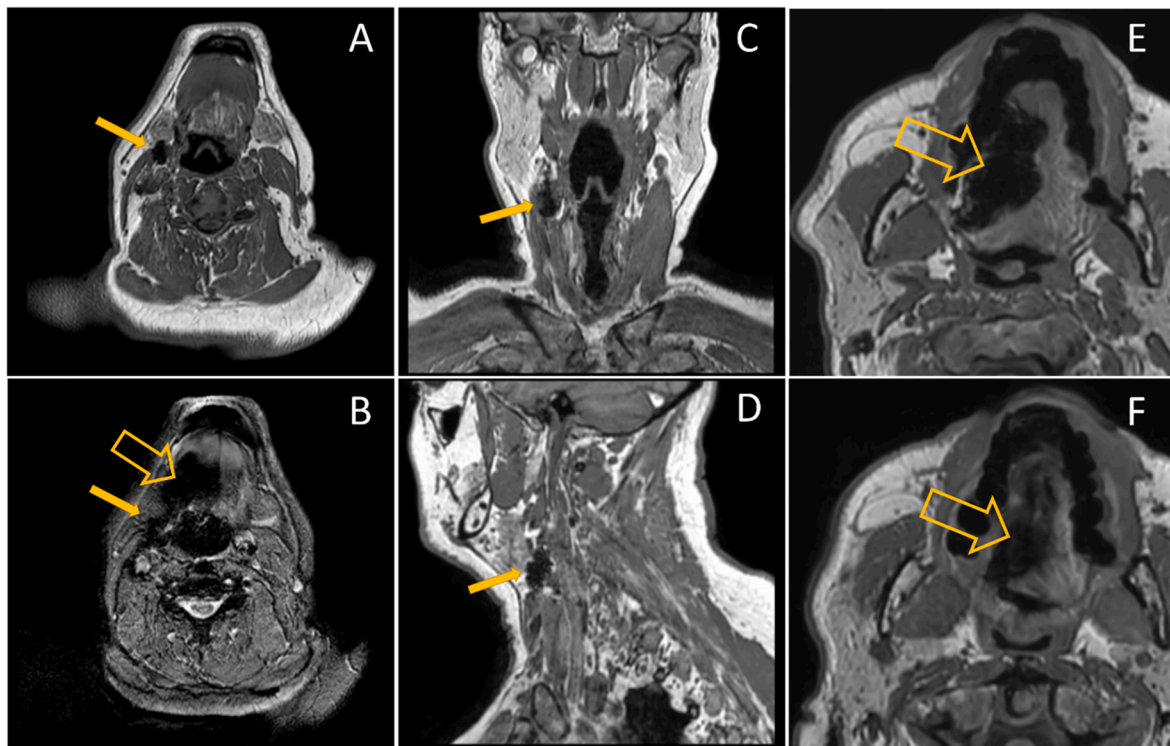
MRI data post magnetic tracer injection (A-E) and post-surgery (F). Solid yellow arrows show SLN (magnetic tracer uptake) in level IIa, right side (A-D). Open yellow arrows show tracer injection sites (B, E and F). (A) T1-weighted MRI (transversal plane); (B) T2-weighted MRI (transversal plane). The open yellow arrow points at the injection site, tumor at right side of tongue; (C) coronal reconstruction of Figure 2A; (D) sagittal reconstruction of Figure 2A; (E) preoperative MRI, the arrow points at the injection site (tumor at right side of tongue); (F) postoperative MRI at location represented in Figure 2E, the arrow points at the residual magnetic tracer.
